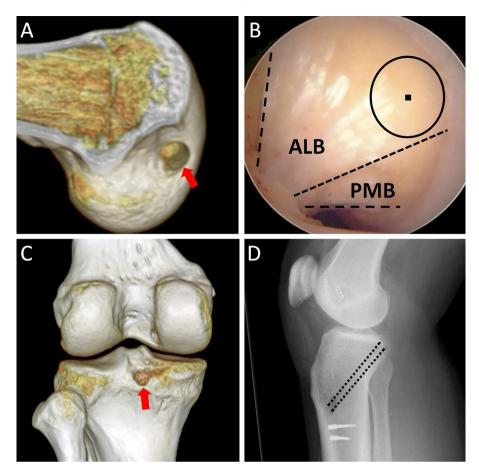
A. Lateral view of a right medial femoral condyle reconstructed from CT image. Femoral bone tunnel is indicated by red arrow. B. Arthroscopic finding of a femoral attachment of PCL. The target point of femoral bone tunnel is the distal portion of the femoral attachment of the anterolateral bundle (ALB) which comes into contact with the anterior articular margin of the medial femoral condyle. C. Posterior view of a right knee reconstructed from CT image. Tibial bone tunnel is indicated by red arrow. D. Lateral radiograph of a right knee after operation. Tibial bone tunnel is indicated by dotted line.
